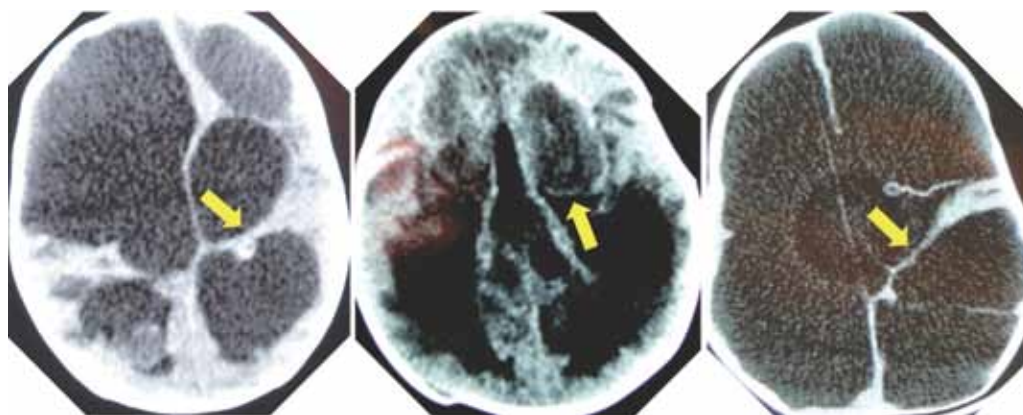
Characteristic CT scans from 3 Ugandan infants younger than 6 months of age at the time of their treatment for PIH. In addition to severe hydrocephalus, frequent evidence of severe scarring and loculations within the ventricular system is visible (arrows).
